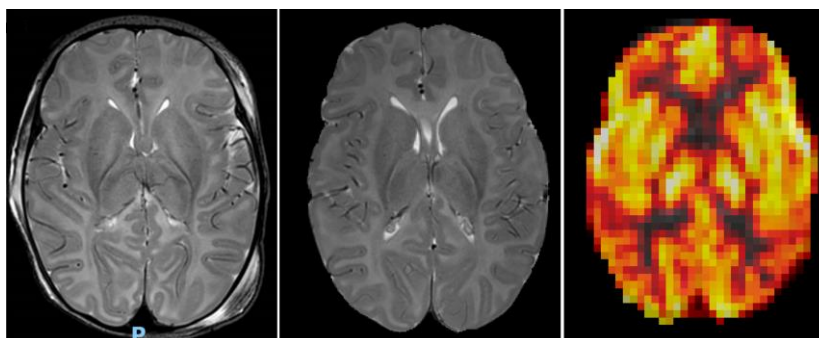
MRI and rCBF map from baby ID6. *T2 images*: NICHD scoring 2B and severe oedema. *rCBF map*: increase perfusion, especially in DGM and cortical areas.
